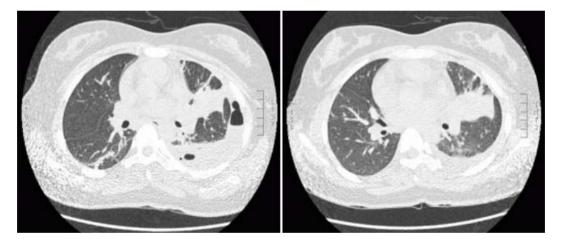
CT showed multifocal consolidation at the LLL basal segment, LUL posterior segment, and LUL lingular division (Abbreviations:LLL, left lower lobe; LUL, left upper lobe).
